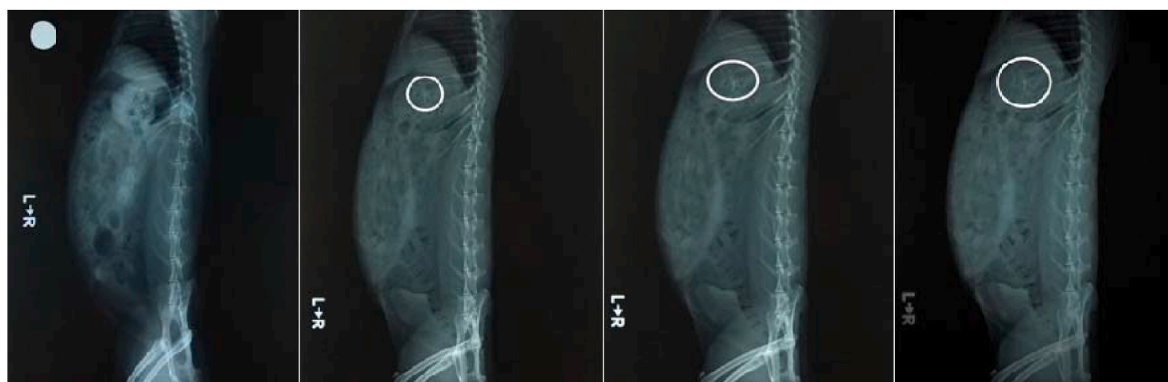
Radiographic images portraying the gastroretentive GRFS containing barium sulphate as a radio opaque marker in the stomach at 0 h, 2 h, 4 h and 6 h (The position of the formulation is pointed by an circle).
